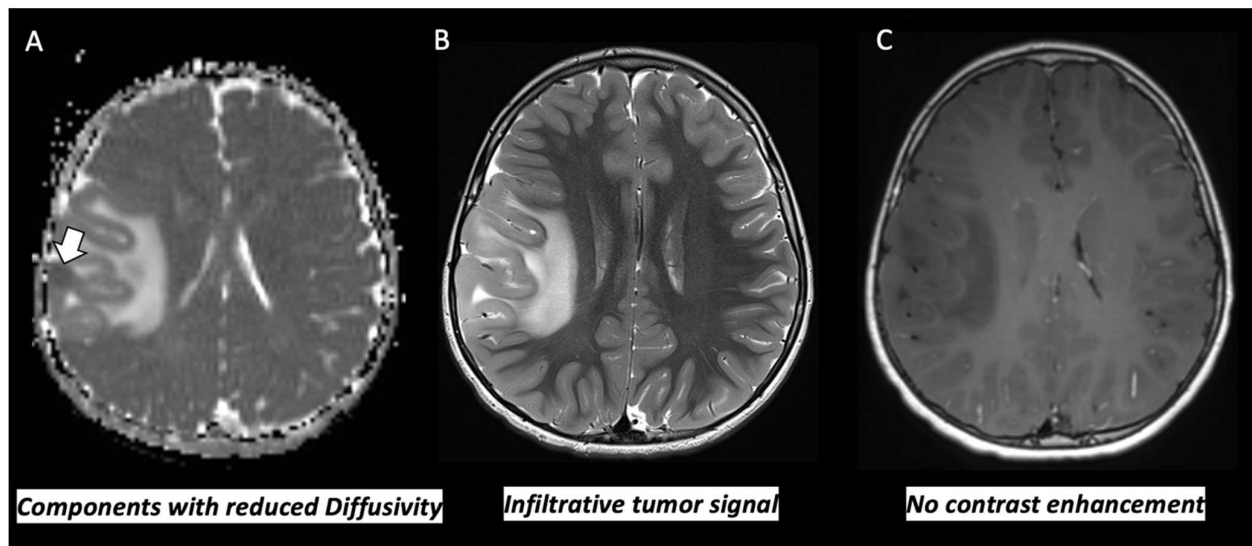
8 years old with *EGFR* altered *H3* WT and *IDH* WT. ADC map, T2-weighted, and T1-weighted post contrast axial images of the brain show an infiltrative tumoral signal involving cortex and subcortical matter of the right parietal lobe. These imaging show a focus of decreased diffusivity (white arrow).
